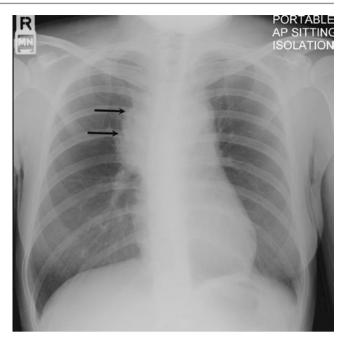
Frontal radiograph shows a distorted contour of the right upper mediastinal border by an anterior mediastinal mass (arrows) that obliterates the normal upper mediastinum
